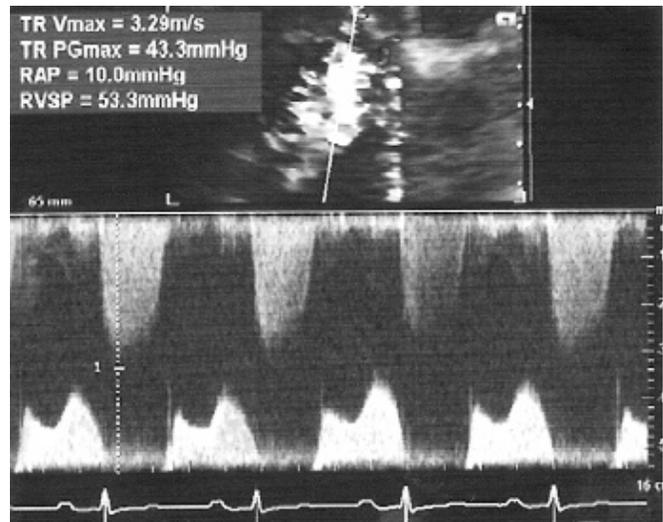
Pulsed Doppler imaging of tricuspid flow showing slow EF slope and concomitant tricuspid regurgitation.
